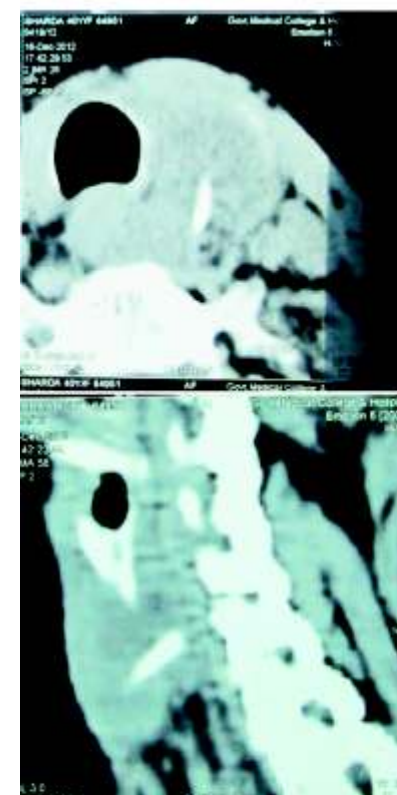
Preoperative CT Neck Images, showing FB of Axial Image (Top) and Sagittal Image (Bottom)
